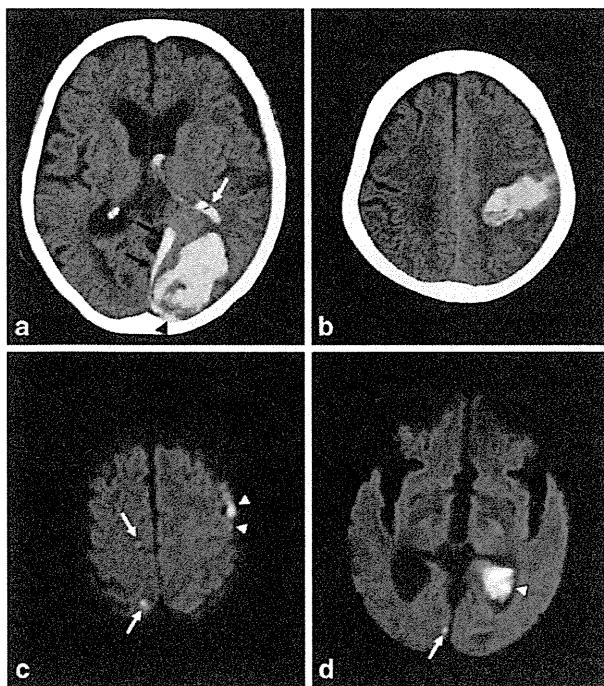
Recurrent CAA-related ICHs associated with intraventricular, subdural and subarachnoid haemorrhages, and microinfarctions in an 87-year-old woman. A CT scan (a) showed left-sided occipital subcortical ICH extending into the left lateral ventricle (*white arrow*), and the subdural (*black arrows*) and subarachnoid space (*arrowhead*) around the occipital lobe. Seven months later, left-sided parietal subcortical ICH recurred and extended into the left ventricle. In addition to these haemorrhagic lesions, asymptomatic cortical microinfarctions (*arrows*) were identified on DWI 12 days after the first (c) and 13 days after recurrent ICH (d). *Arrowheads* indicated subdural, subarachnoid and intraventricular haemorrhages
